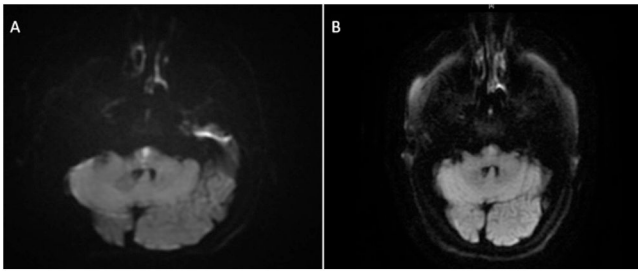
Transverse brain MRI scan, diffusion sequence. A) Restricted diffusion in the lower paramedian pons. B) Decreased signal intensity associated with subacute stroke.
